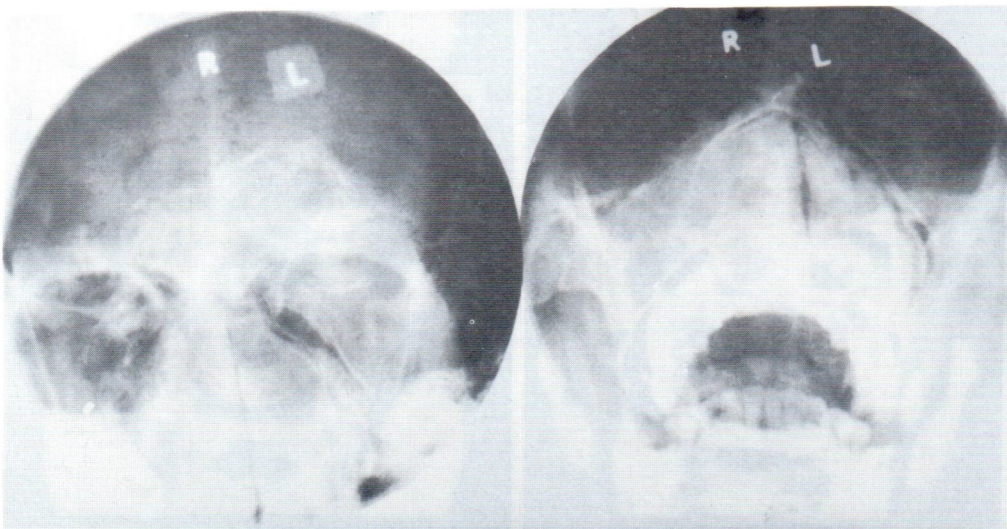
Case 2. Plain film of the face in AP and Water's views showed a densely and both frontal sinuses. There was an expansion of both nasal calcified or ossified mass in the region of both ethmoid sinuses, cavities and ethmoid sinuses.
